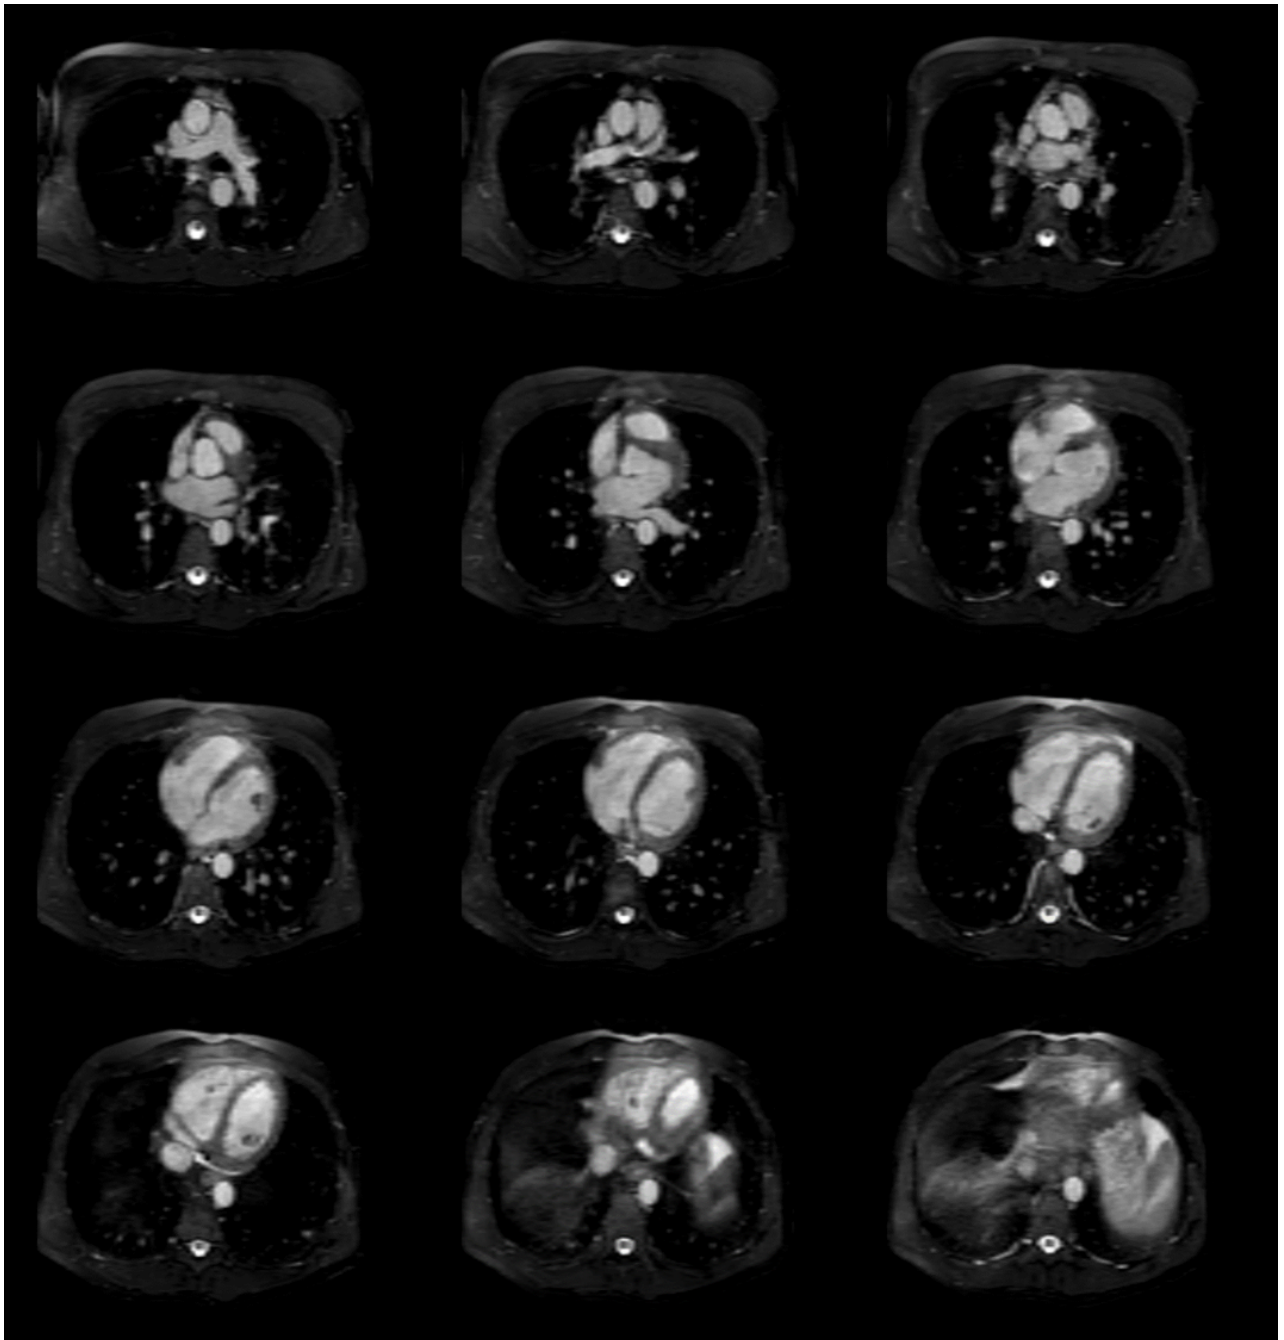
The axial view for the MRI of the first volunteer. Each picture represents one axial layer of the MRI, the distance between the axial layers is 10.5 mm and the original resolution distance is 1.5 mm
